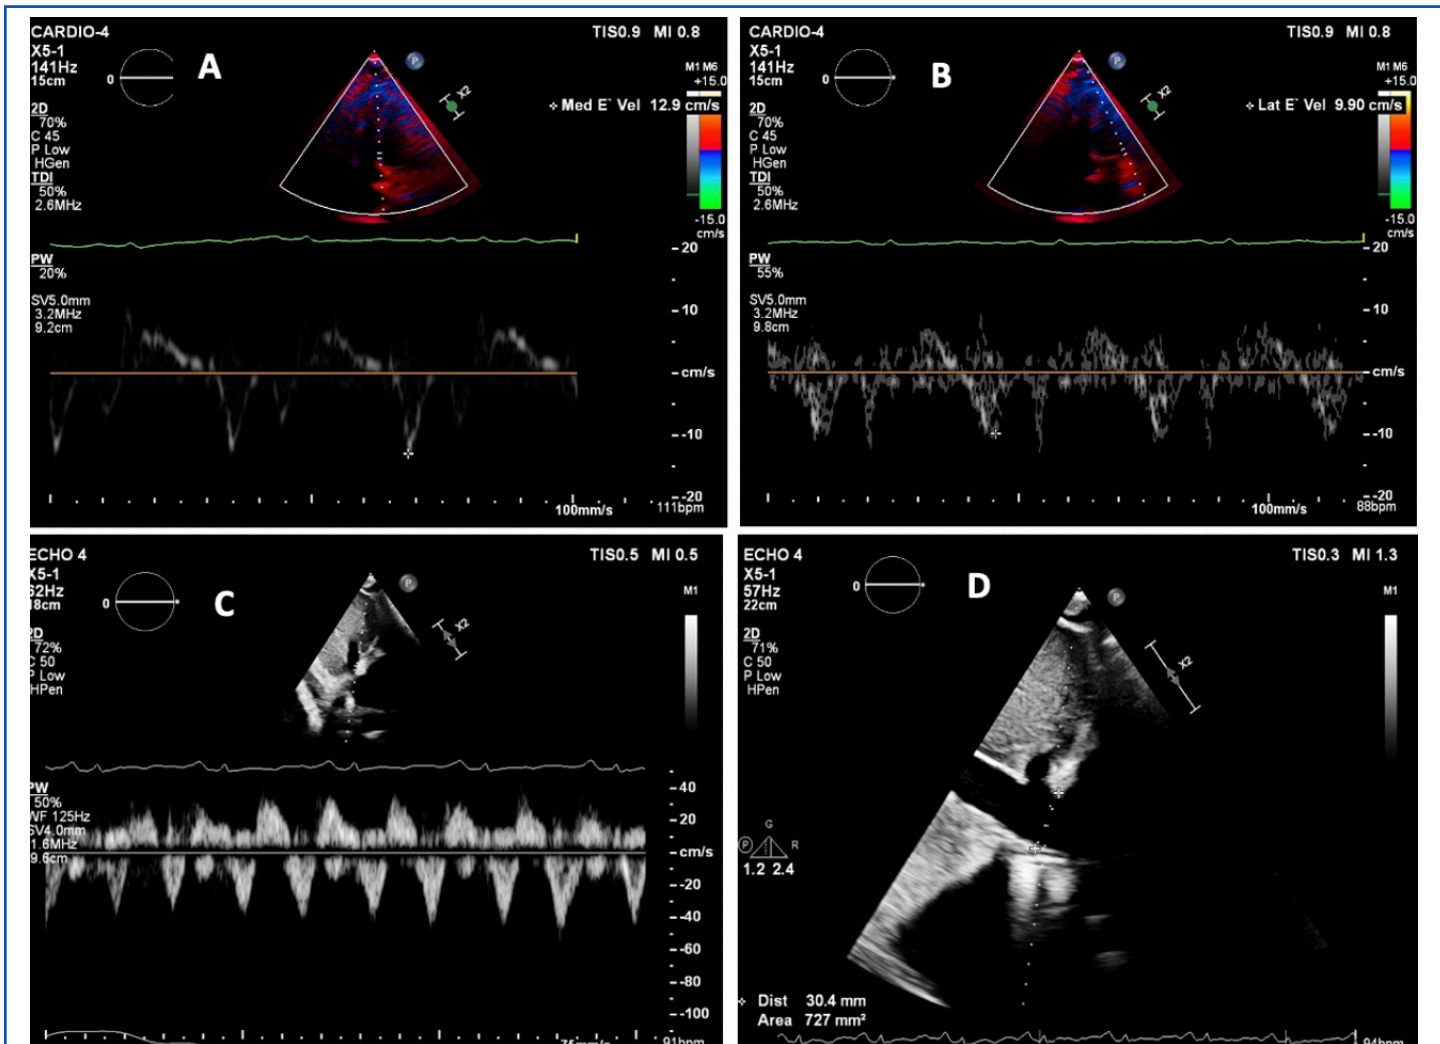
Echocardiographic red flags. A, B: "Annulus paradoxus" with medial annular E' (12.9 cm/s) higher than lateral annular E' (9.9 cm/s); C: Hepatic vein PW Doppler profile with diastolic flow reversal; D: Dilated inferior vena cava (30 mm) with no respiratory variations
